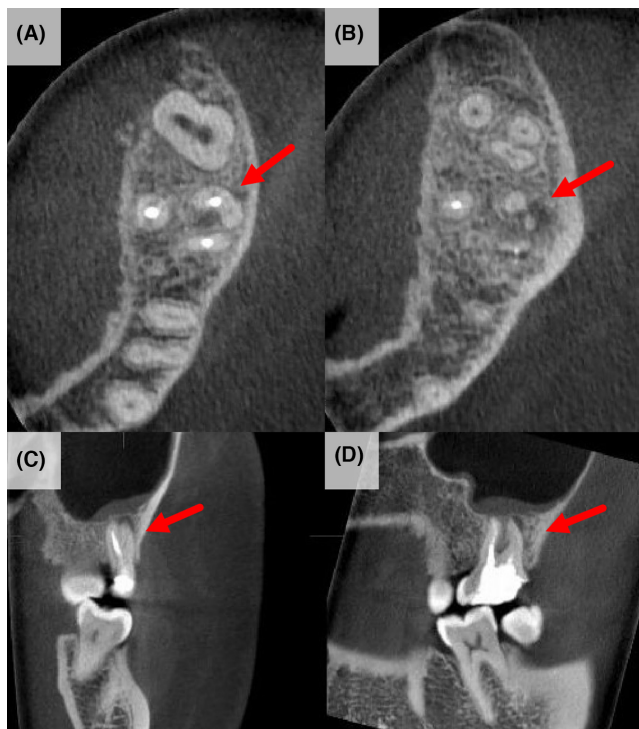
Cone beam computed tomography images of tooth 26 before retreatment of the root canal. (A) Cross-sectional view; the red arrow indicates an extra distobuccal canal (DB₁) with no visible root canal filling. (B) Cross-sectional view; the red arrow indicates the radiolucent lesion adjacent to the distobuccal root apex. (C) Coronal view; the red arrow indicates the missed second distobuccal canal. (D) Sagittal view; the distobuccal root was surrounded by a radiolucent periapical area.
